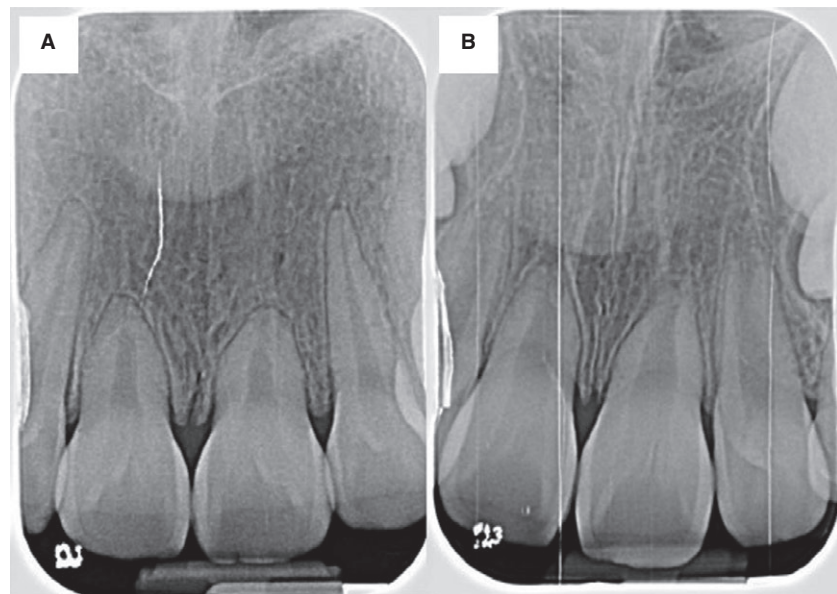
(A) A periapical radiograph of the 12-year-old daughter of the proband (III:4). (B) A periapical radiograph of the 8-year-old son of the proband (III:7).
